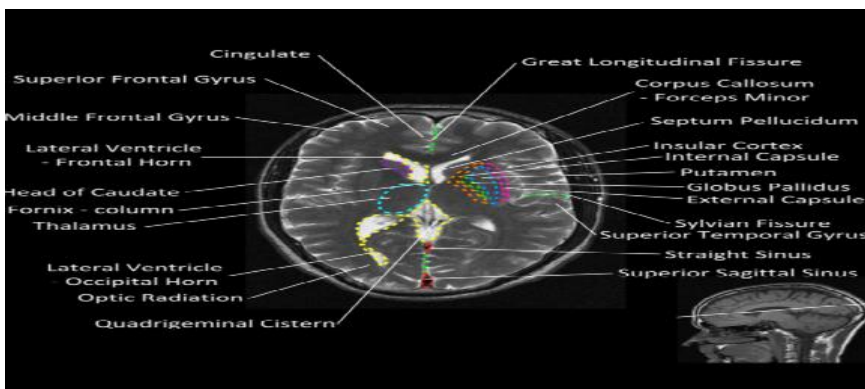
showing MRI Brain -normal axial view of thalamic region
